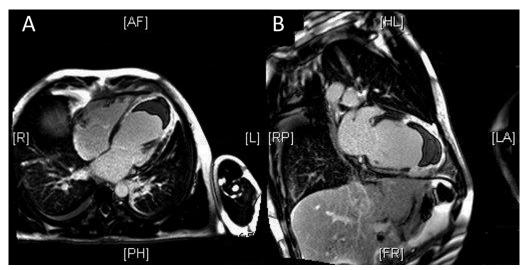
Cardiac MRI from four-chamber (A) and two-chamber (B) views after gadolinium injection. These show evidence of late gadolinium enhancement at the LV apex. Dense material is seen at the LV apex, representing thrombus within this region. AF, Anterior; FR, inferior; HL, high lateral; L, left; LA, left anterior; PH, posterior; R, right; RP, right posterior.
